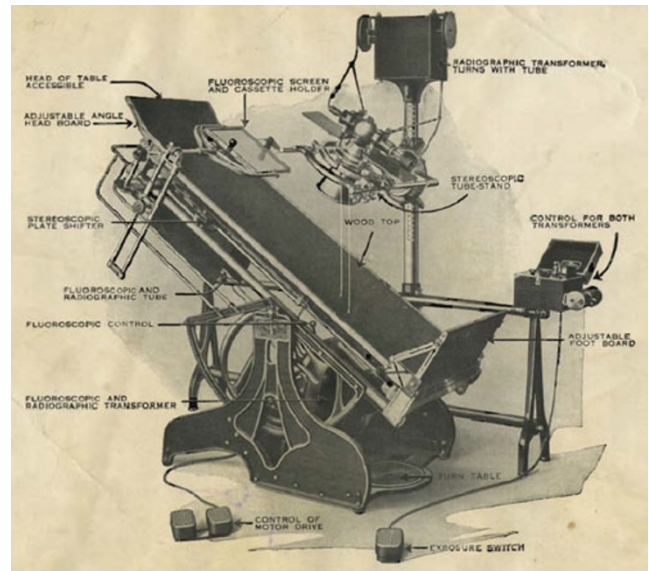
The “trolleyless” Clinix from Campbell which had two transformers and two X-ray tubes limiting dangerous wiring (about 1920) [49]
